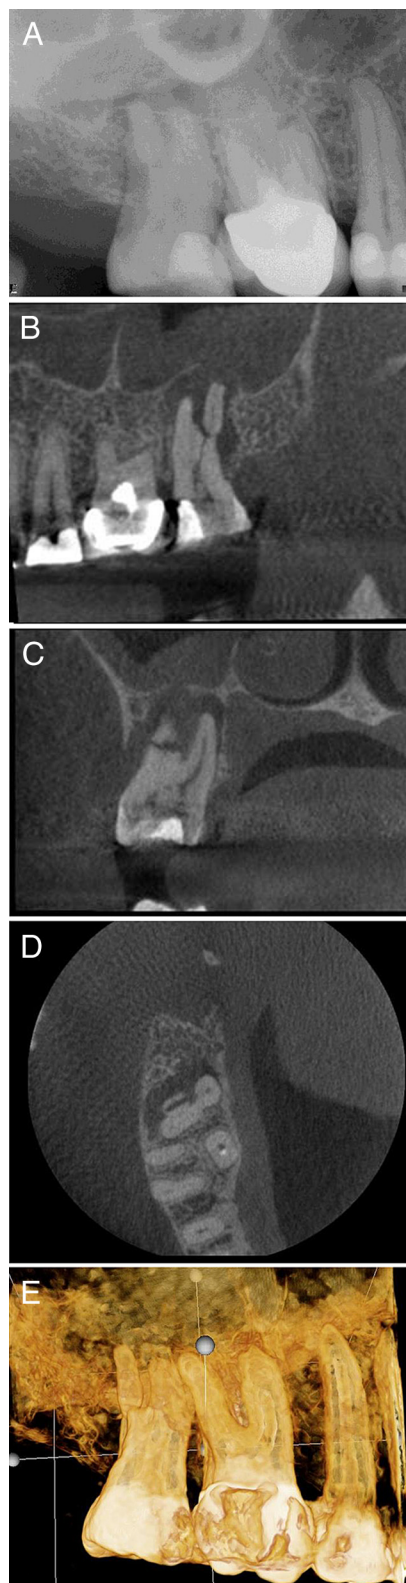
Case 2: *A*) A periapical radiograph of tooth #2. The patient was referred for nonsurgical root canal treatment with a diagnosis of pulp necrosis and asymptomatic apical periodontitis. *B*) A sagittal view showing the distobuccal root fracture. *C*) A coronal view showing the unusual horizontal fracture of the distobuccal root. *D*) An axial view of the apical one third showing a vertical buccopalatal root fracture. *E*) A 3D reconstruction showing the extent of the distobuccal root fracture.
